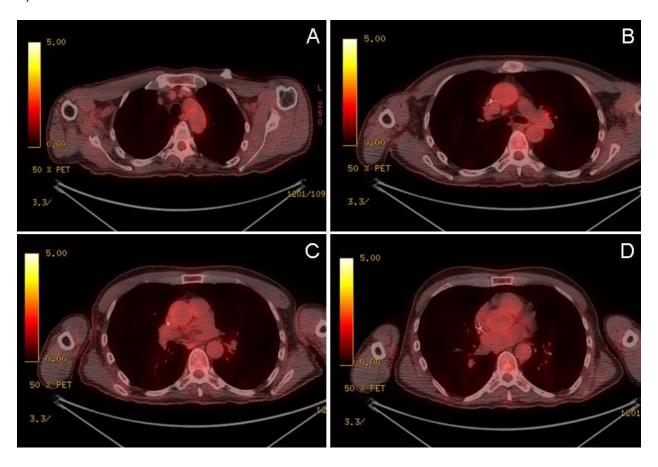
Representative images from PET/CT of chest 3 months after nivolumab and ipilimumab were stopped and corticosteroids were begun.
